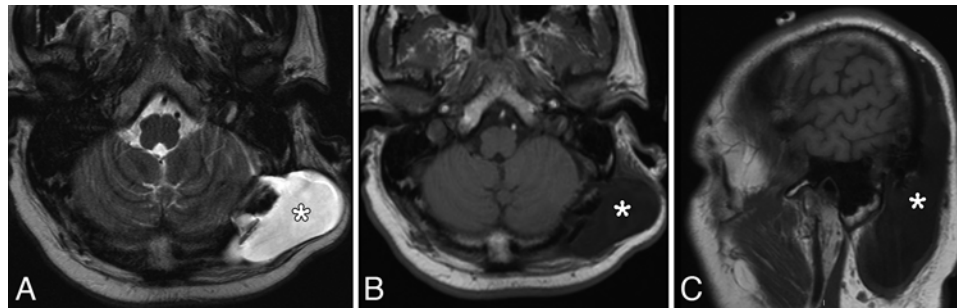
Pseudomeningocele. Axial T2-weighted (A), axial T1-weighted (B), and sagittal T1-weighted (C) MRI studies showing a large subgaleal fluid collection (asterisk) that communicates with the intracranial CSF across the left retrosigmoid craniotomy.
